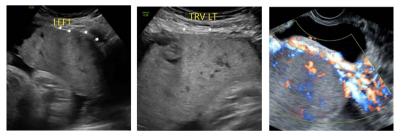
Ultrasound imaging concerning for placenta accreta in Twin A. Loss of demarcation between placenta and myometrium (left, middle). Prominent vessels abutting the bladder (right).
